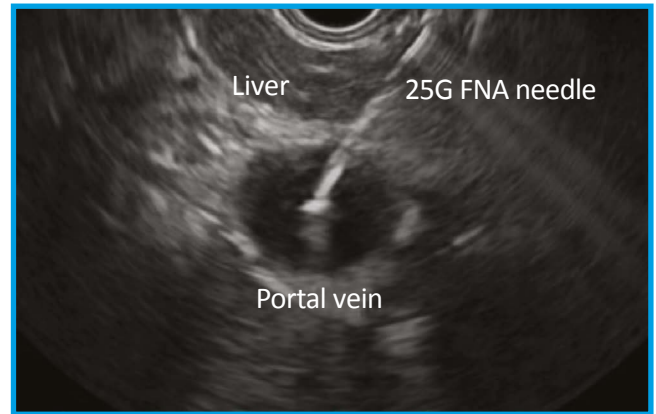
Endoscopic Ultrasound Image of transgastric transhepatic needle puncture into the portal vein with a 25G FNA needle (from Huang 2016)
